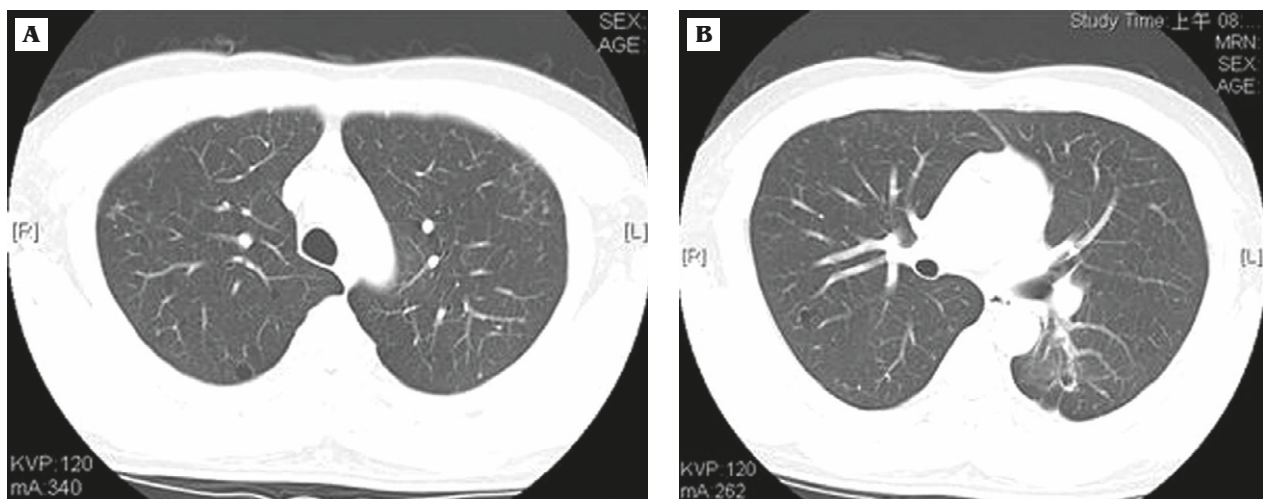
Computed tomography scans (at levels similar to Fig. 2) obtained 8 months after the start of antituberculous chemotherapy show regression of the thin-walled cystic lesions in both lungs.
